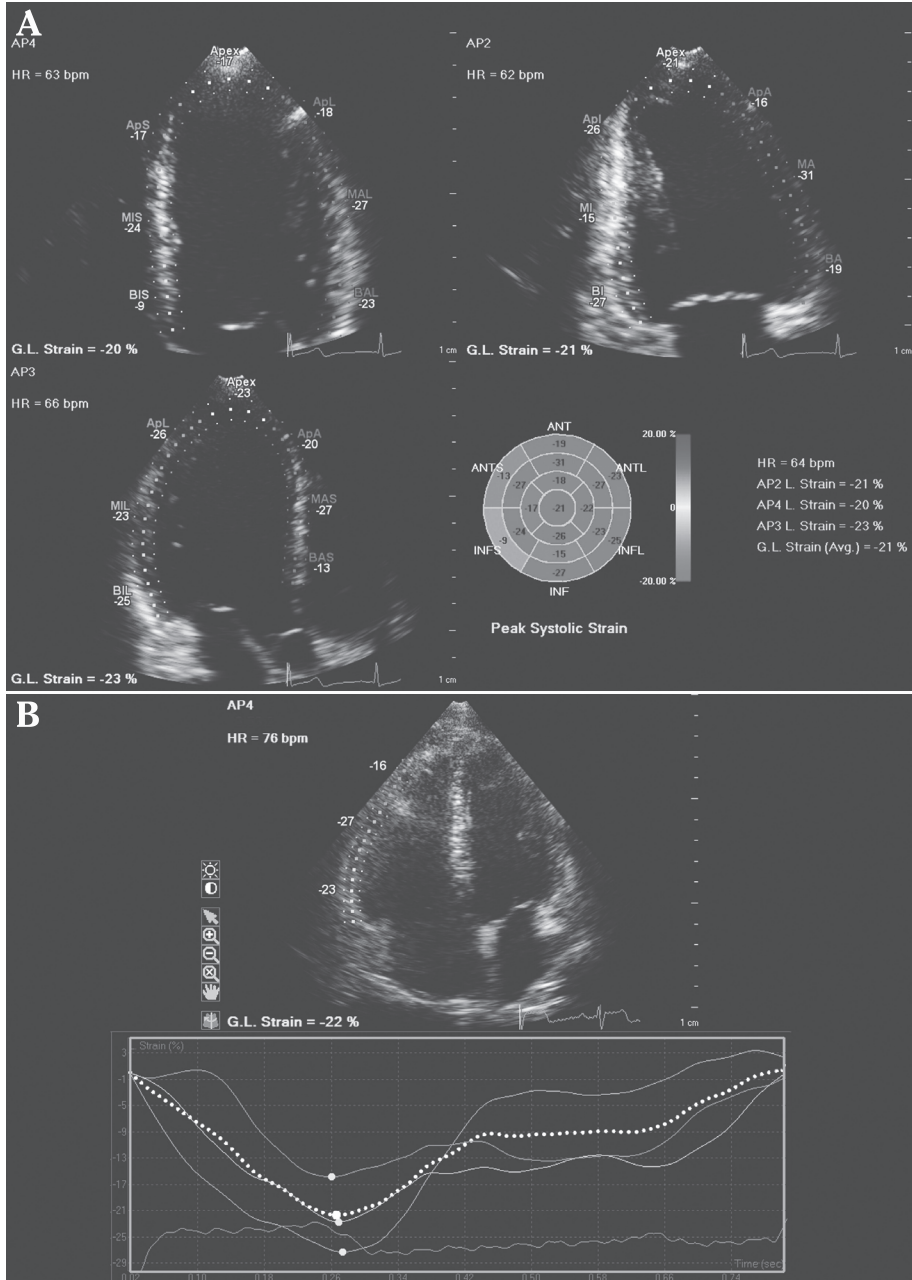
Left-ventricular (A) and right-ventricular (B) longitudinal strain measurements. The left ventricle was traced at the apical four-, two-, and three-chamber views at end diastole. The walls were automatically divided into seven segments at each view. The segmental strain measurements were plotted in a bull's eye and the left-ventricular global longitudinal strain was calculated. The right-ventricular lateral wall was traced from base to apex at end diastole. The lateral wall was automatically divided into three segments. The global longitudinal strain of the lateral wall was calculated from these three segments. AP4, apical four-chamber view; AP2, apical two-chamber view; AP3, apical three-chamber view; GL, global longitudinal.
